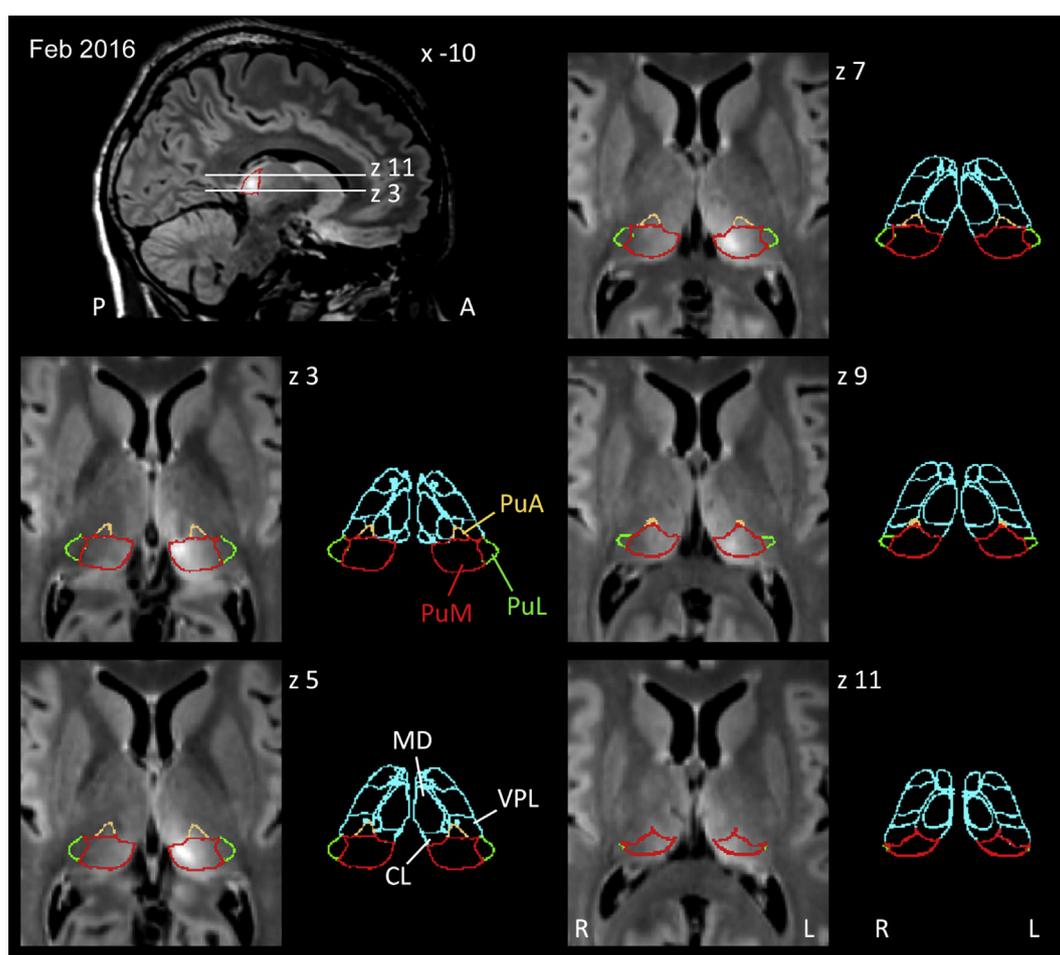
Lesion reconstruction of patient M.B. Magnified views of fluid-attenuated inversion recovery (FLAIR) MR images of patient M.B. in MNI-space, co-registered to the digital version of the Morel atlas. Images were acquired in February 2016 when the behavioral testing took place. The top left shows a sagittal section indicating the orientation of the axial cross-sections. FLAIR images show hyperintensity in the medial pulvinar on both sides, stronger in the left pulvinar (radiological convention with left hemisphere shown on the right side). Lesions spared the ventral pulvinar portions, anterior thalamus, brainstem, cerebellum and surrounding cortices. Cross-sections show the lesioned thalamic regions based on the overlaid pulvinar regions defined by the Morel atlas. Corresponding sections of the Morel atlas with all regions are shown on the right to the FLAIR images. The thalamic regions from the Morel atlas are outlined in light blue, except for medial pulvinar (PuM, red), lateral pulvinar (PuL, green), and anterior pulvinar (PuA, orange). A: anterior; CL: central lateral nucleus; L: left; MD: mediodorsal nucleus; P: posterior; R: right; VPL: ventral posterior lateral nucleus. x, z (in mm) denote the level of the cross-sections in MNI-space.
